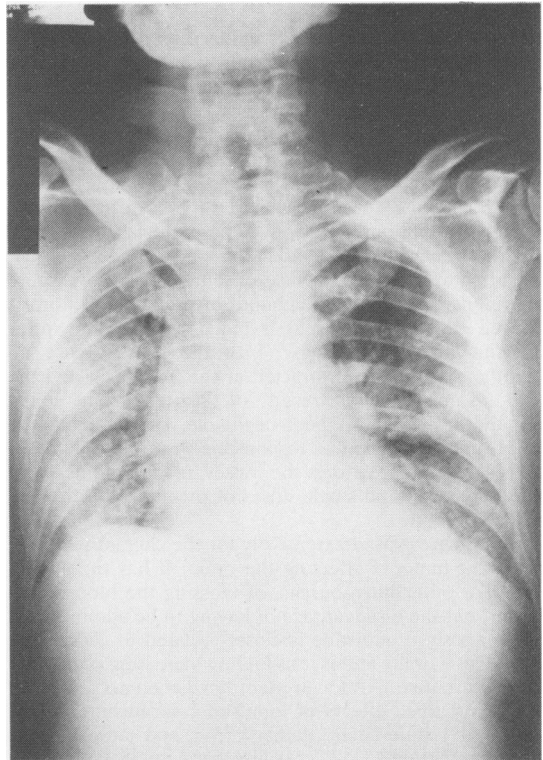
Chest radiograph showing widespread reticulonodular shadowing: antero-posterior film at time of admission to hospital.
